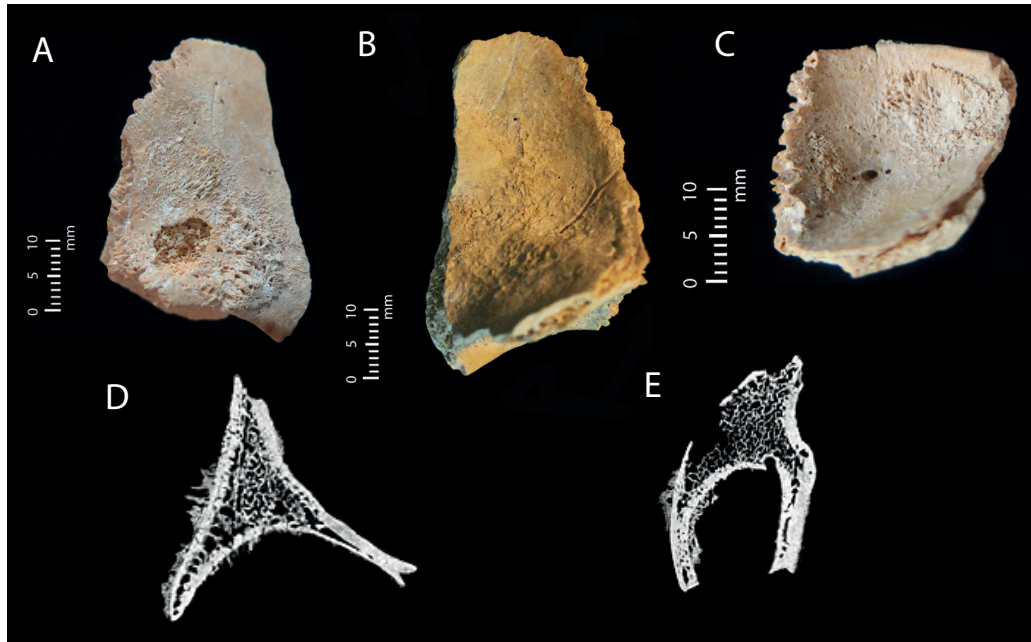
Photographic and radiological images pertaining to fragment of non-adult frontal (FB0040) from Context (960) displaying extensive periosteal lesions, including: a) antero-lateral view of the ectocranial surface, with woven bone superior to the supraorbital margin and truncated by postmortem taphonomic erosion; b) endocranial view displaying woven bone and capillary impressions; c) inferior view of right orbital roof presenting islands of woven bone; d) sagittal cross-section from CT data through the mid-point of the orbit displaying spiculated new bone on the supraorbital margin, infraorbital surface and pars orbitalis; e) sagittal cross-section through the lateral aspect of the orbit, displaying woven bone on the supraorbital margin and infraorbital surface. Scale bar: 1 cm (photographs only). (Photos Jess E. Thompson; radiological images captured by L. Buck, Cambridge Biotomography Centre; processed by J. Magnussen & M. Pardey, Macquarie Medical Imaging).
